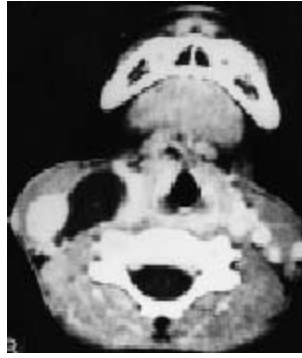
Axial contrast-enhanced CT of the neck shows the cyst appearing as a hypodense, non-enhancing lesion, bounded laterally by the internal jugular vein and the sternocleidomastoid muscle and medially by the carotid artery and the longus colli muscle.
